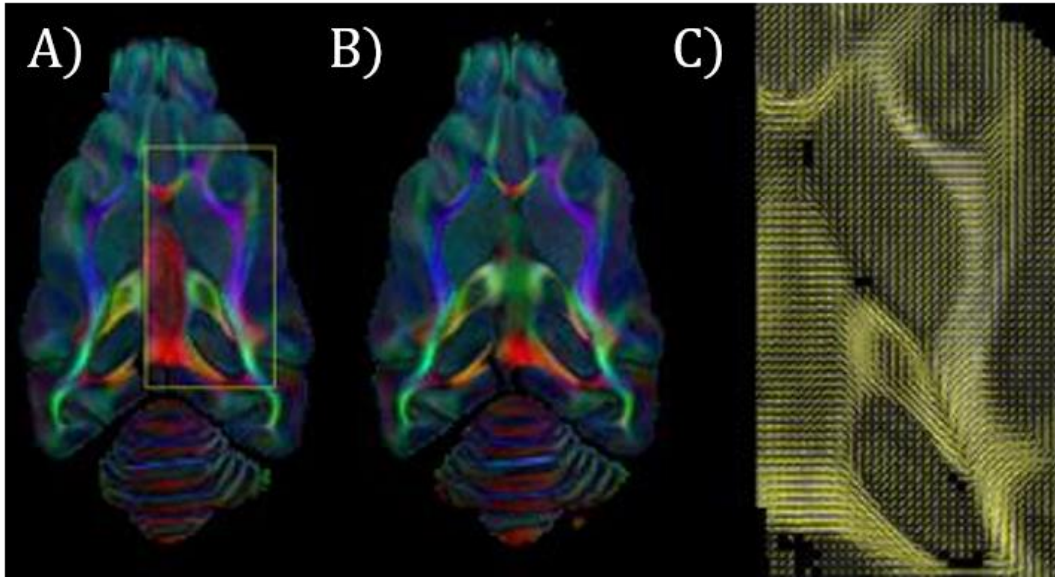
Diffusion tensor images (DTI) of structural anisotropy in the ferret brain. Diffusion, measured by MR imaging sequences, is faster along the dominant fiber direction. (A-B) The direction of maximum diffusivity is indicated by color (red = left-right; green = front-back; blue = up-down). Brightness indicates the magnitude of diffusion anisotropy. (C) Vector field of dominant fiber direction inferred from the direction of maximum diffusivity for the zoomed-in area outlined in (A). Figure reproduced from proposal CMMI-1332433 (PI: PV Bayly).
